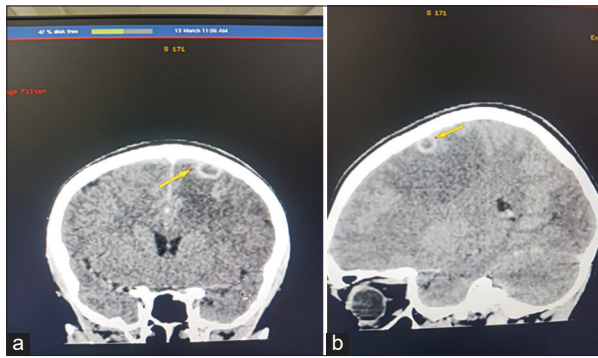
(a) Contrast-enhanced computed tomography (CECT) Brain - axial and coronal views demonstrate a solitary, ring-enhancing lesion located in the left high parietal lobe (yellow arrows). There is evidence of significant perilesional hypodensity, consistent with vasogenic edema associated with neurocysticercosis (Source: A.P. Diagnostic and Imaging Centre, Dhanbad, Jharkhand); The yellow arrow points to a small, well-defined, circular, hyperdense lesion located within the brain parenchyma, close to the inner table of the skull. (b) CECT brain montage comprehensive view of the cranial sections showing the anatomical distance between the parietal lesion and the pituitary region (Source: A.P. Diagnostic and Imaging Centre, Dhanbad, Jharkhand)
